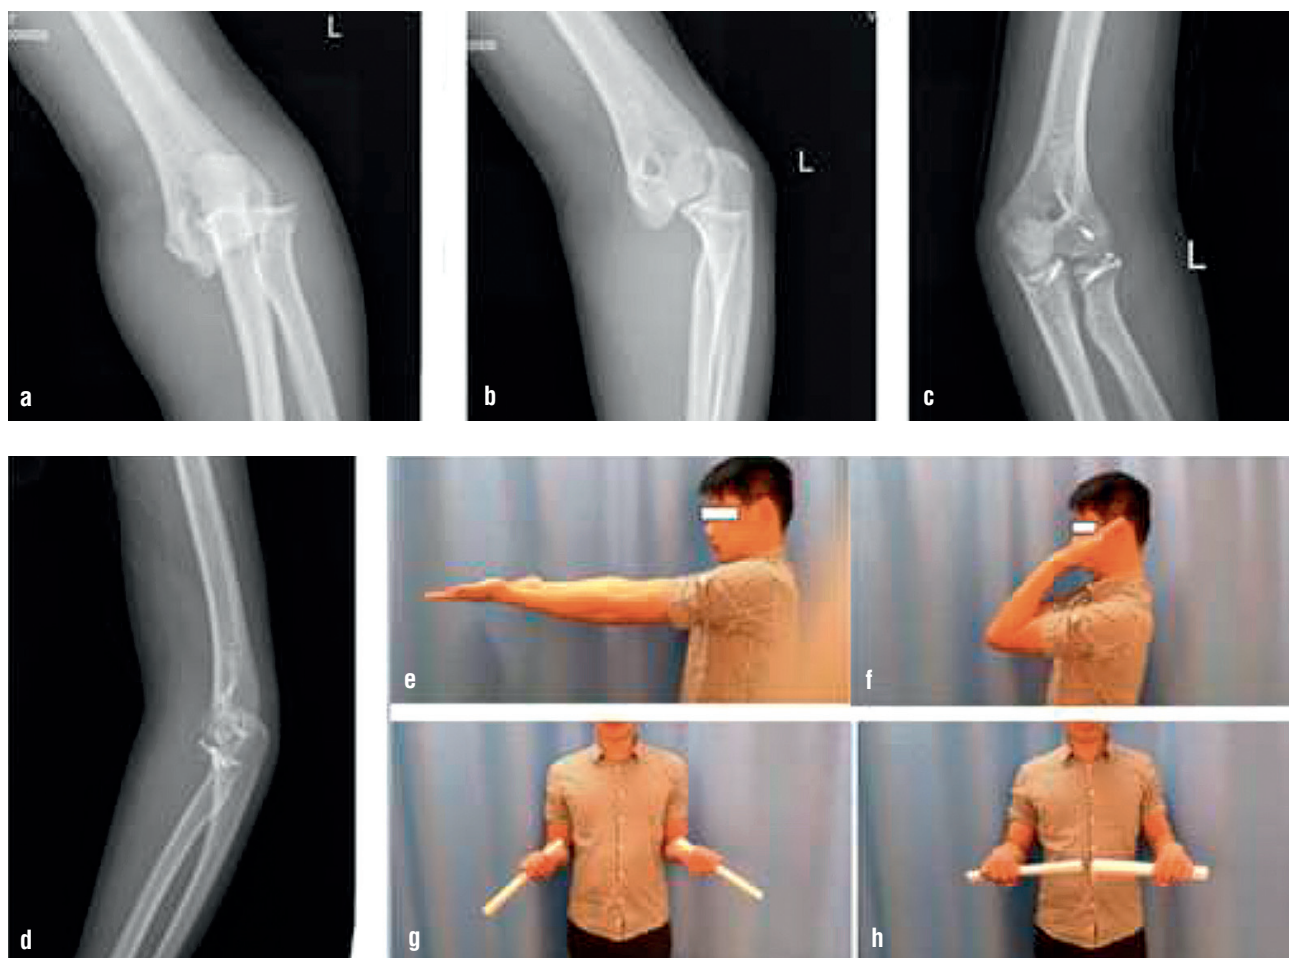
A 31-year-old man with a terrible triad injury and MCL injury of the right elbow. Preoperative anteroposterior (a) and lateral (b) radiographs demonstrating a comminuted type II coronoid fractures and a comminuted type II radial head fractures. Postoperative anteroposterior (c) and lateral (d) radiographs demonstrating fixation of the coronoid fractures and radial head fractures with 2 MCSs respectively. Elbow range of motions at follow-up (e–h).
